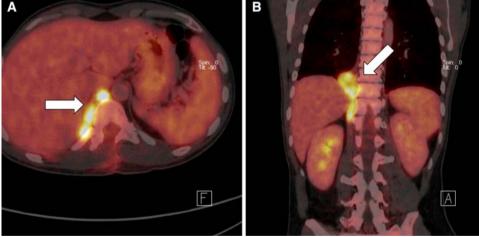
Axial PET/CT scan (a) and coronal PET/CT scan (b) of the whole body after the first operation showed a right paravertebral tumor T10 with no
